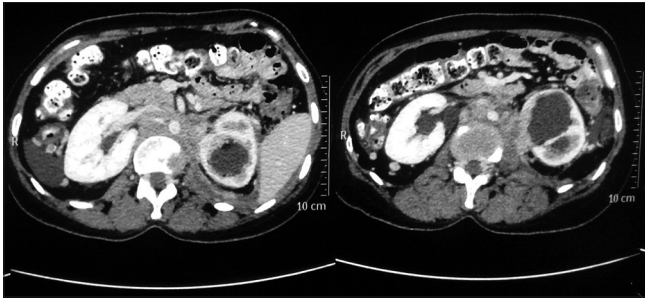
Computed tomography scan showing multiple para-aortic lymph node metastases
